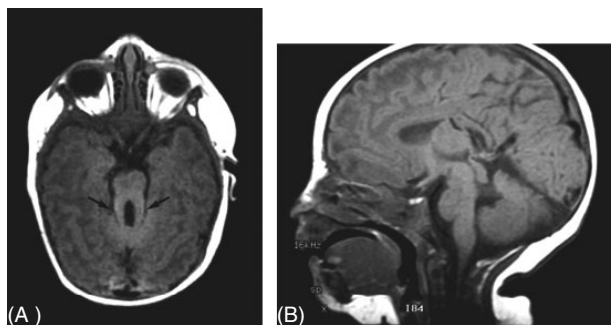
MRI of Case 1 older sibling with Joubert syndrome at 1 month of age. (A) Axial view: thick, elongated superior cerebellar peduncles, the deep interpeduncular fossa is visible in an adjacent slice. (B) Midline sagittal view: abnormal configuration of the 4th ventricle, the hypoplastic vermis is difficult to distinguish from the cerebellar hemispheres impinging on the midline slice
